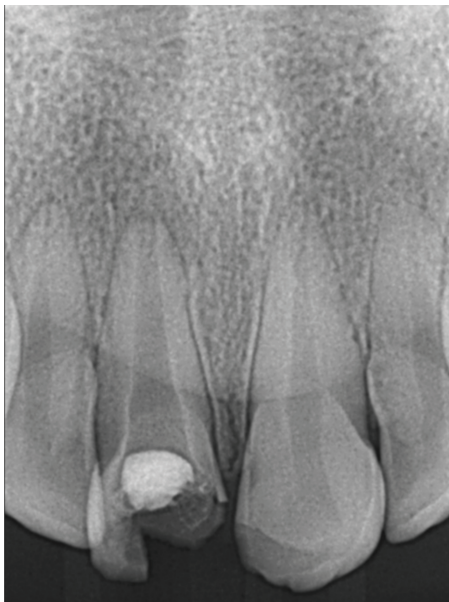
Intra-oral radiograph after emergency treatment. (Far left)
